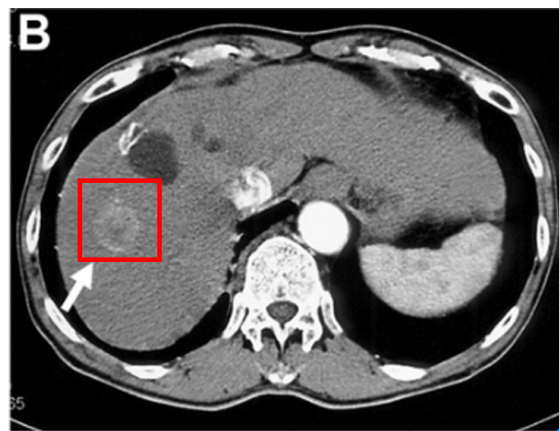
Arterial phase CT image of the HCC liver lesion (Masakatsu Tsurusaki, July 2014)
